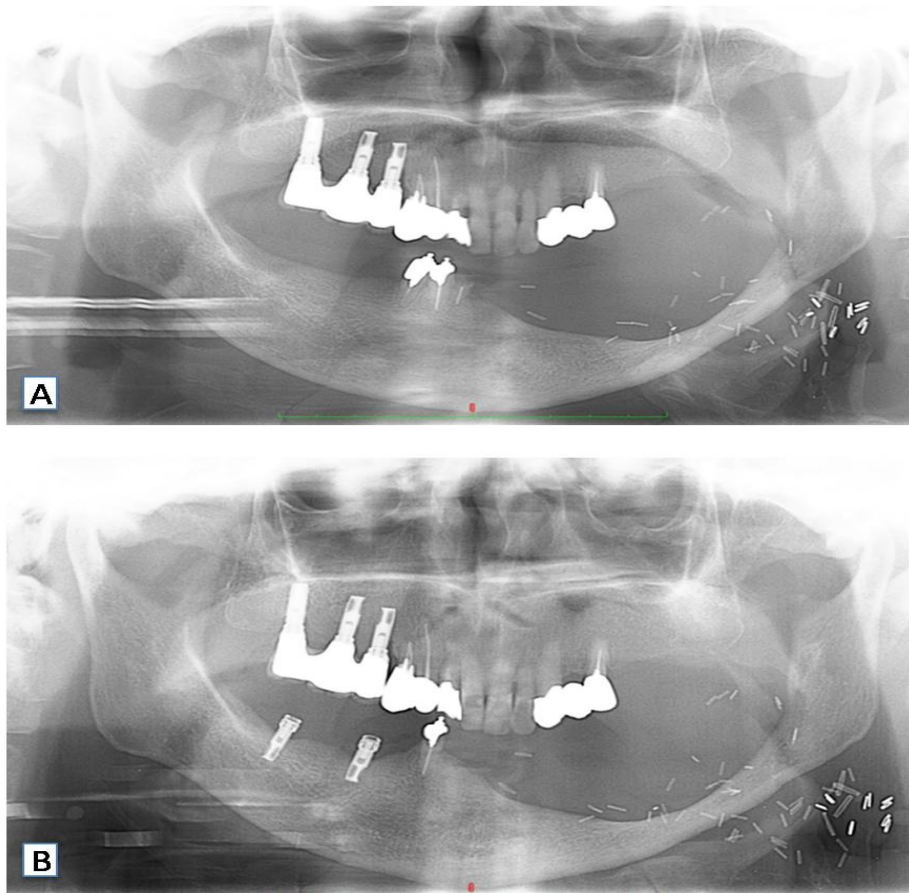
(a) Panoramic radiograph showing the preoperative condition before implant placement; (b) Panoramic radiograph after placement of the 2 dental implants
